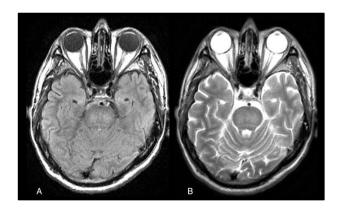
Brain magnetic resonance imaging in axial sections at the pontine level (A) FLAIR and (B) T2 with diffuse hyperintensity of central bridge distribution.
